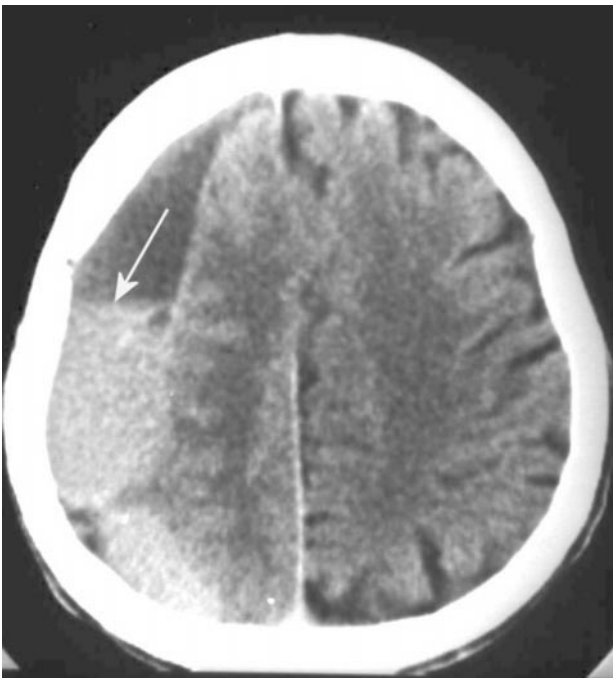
CT axial chronic subdural hematoma - rebleeding (fluid -fluid level)
